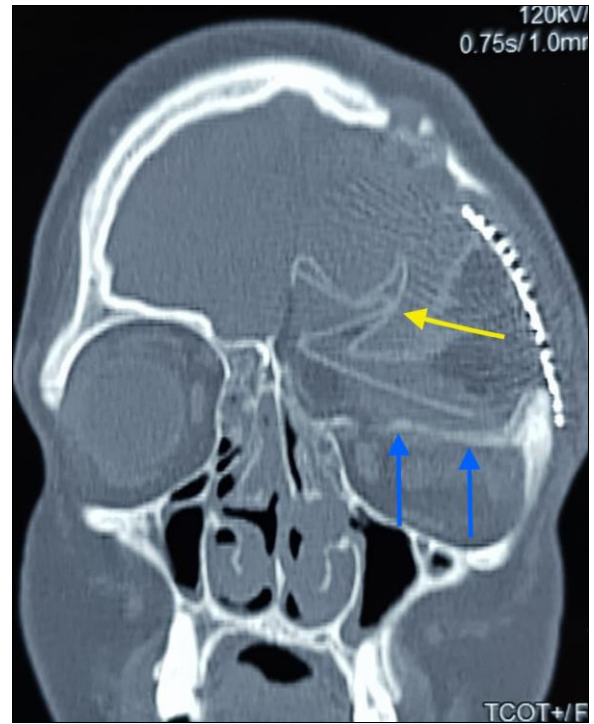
Inadequate placement of titanium mesh, an unknown graft material (yellow arrow) also visible in CT scan slice, this came out to be PTFE membrane. Also notice the depressed orbital roof reconstructed with synthetic material (blue arrows).
